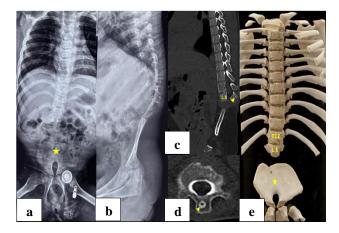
(a) X-ray AP view whole spine, (b) X-ray lateral view shows total sacral atresia and partial lumber atresia with midline fusion of bilateral iliac blades (star) (shield sign), (c) sagittal, and (d) axial CT images showing dysplastic L1 vertebra with bifid spine (Arrowhead), and (e) virtual reconstructed image of CT scan showing total sacral and L2–L5 vertebrae atresia with midline fusion of bilateral iliac blade (star), with no articulation with the dysplastic L1 vertebra.
